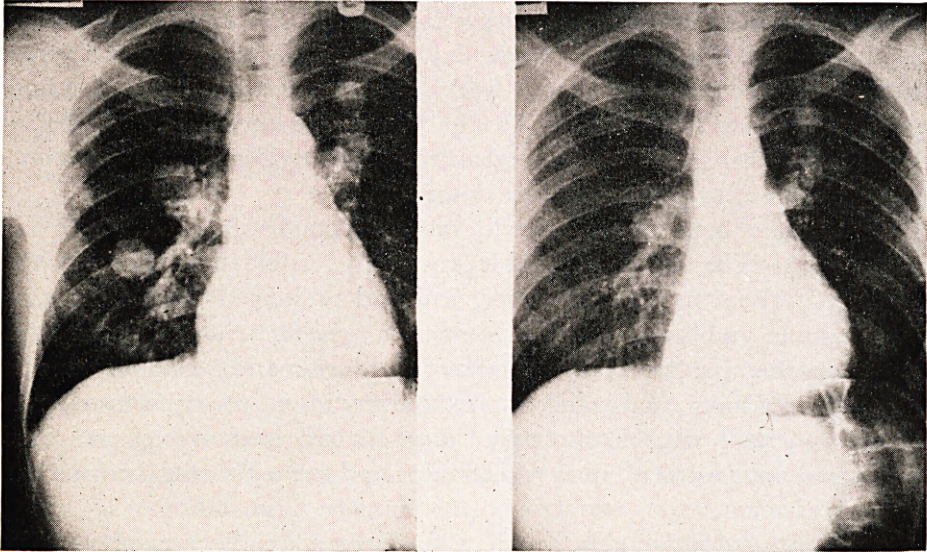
X-rays taken before and after combination chemotherapy with vincristine, natulan, nitrogen mustard, and prednisone in a man aged 27 with teratoma of the testis, which had failed to respond to all other forms of chemotherapy, showing regression of some of the pulmonary metastases.
